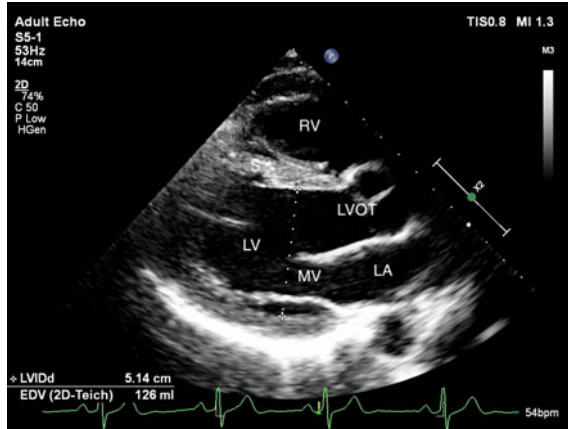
Parasternal long axis view at end-diastole showing right ventricle (RV), septum (S), left ventricle (LV), left atrium (LA), mitral valve (MV) and left ventricular outflow tract (LVOT, including aortic valve)
